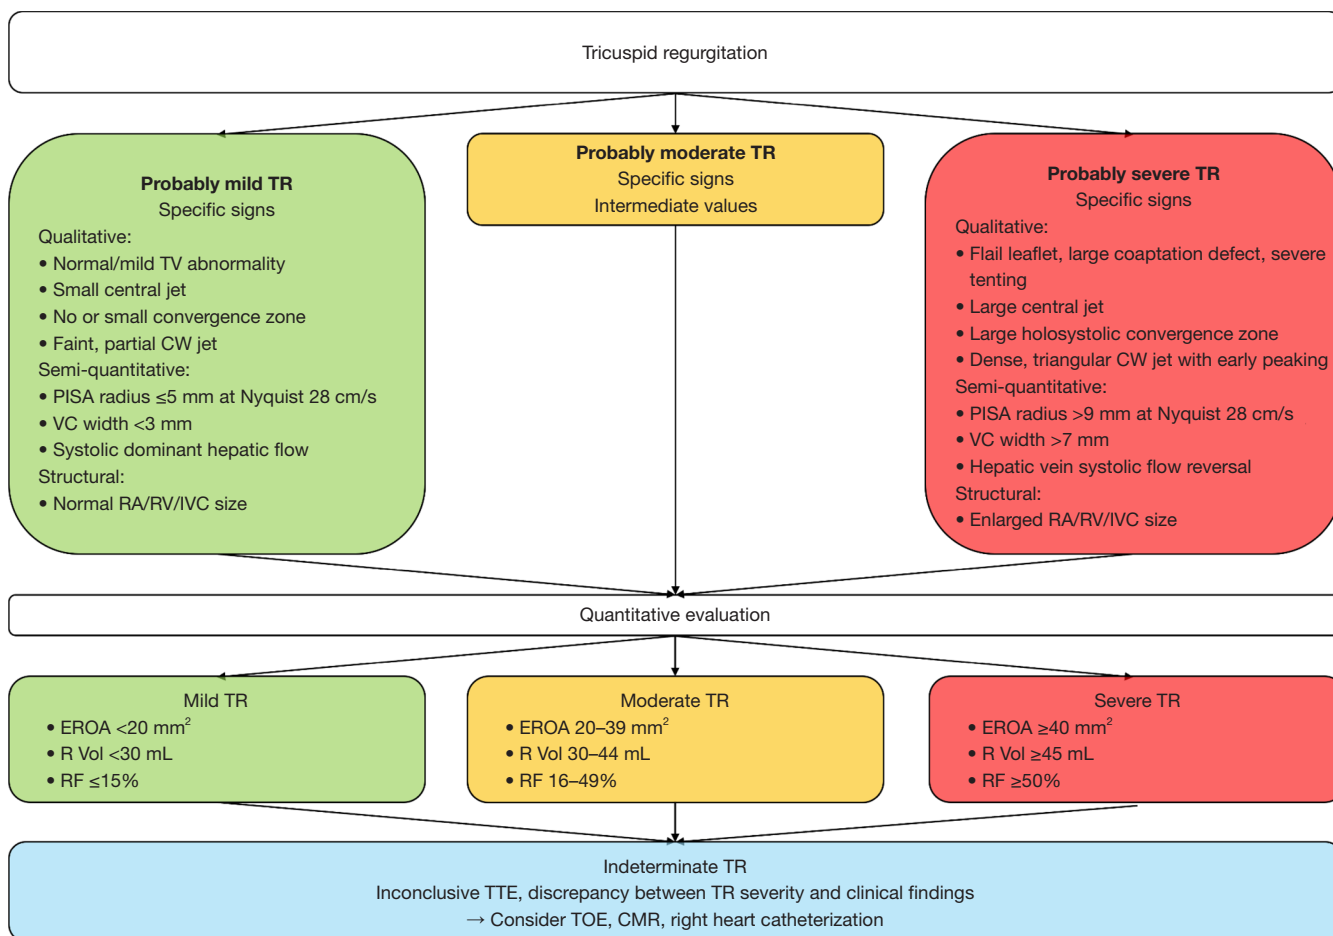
Algorithm for the assessment of tricuspid regurgitation severity. Adapted according to (15). CMR, cardiac magnetic resonance imaging; CW, continuous wave; EROA, effective regurgitant orifice area; IVC, inferior vena cava; PISA, proximal isovelocity surface area; R Vol, regurgitant volume; RA, right atrium/right atrial; RF, regurgitant fraction; RV, right ventricle/right ventricular; TOE, transesophageal echocardiography; TR, tricuspid regurgitation; TTE, transthoracic echocardiography; TV, tricuspid valve; VC, vena contracta.
